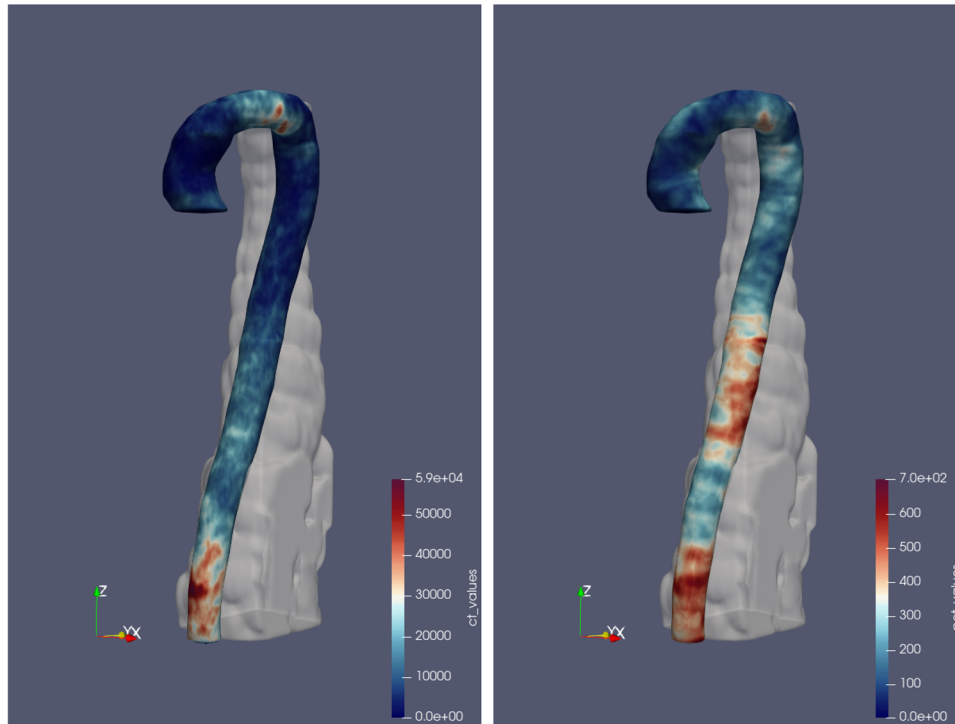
Calcium distribution on CT (left) and Na¹⁸F distribution (right) of the entire population. In transparent white, the dilated vertebral mask of the “median patient” is shown.
